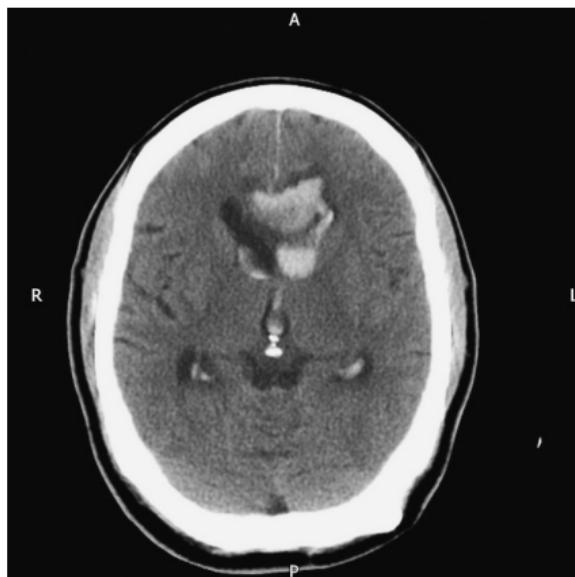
CT showing acute subarachnoid haemorrhage following rupture of berry aneurysm.
